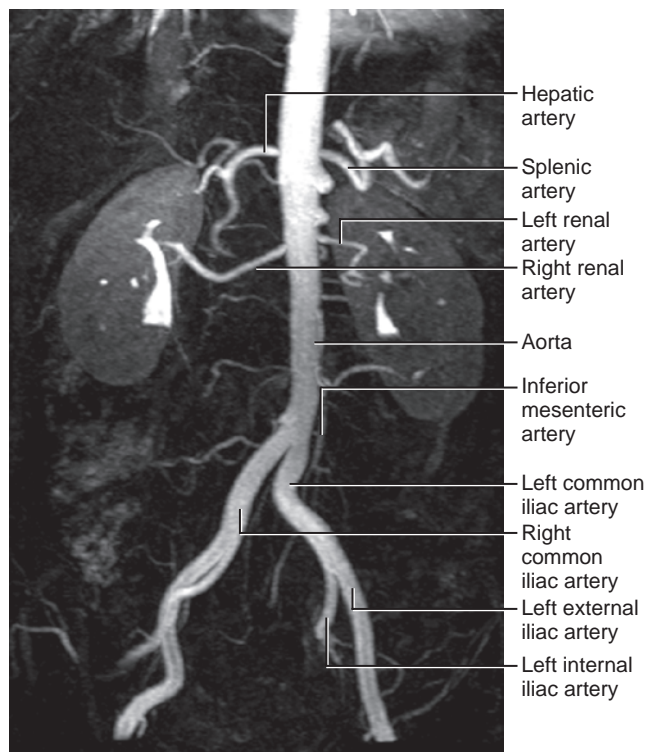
Computed tomography angiogram of the abdominal aorta and its branches. (From MacLennan GT. *Hinman's atlas of urosurgical anatomy*. 2nd ed. Philadelphia: Saunders; 2012.)
